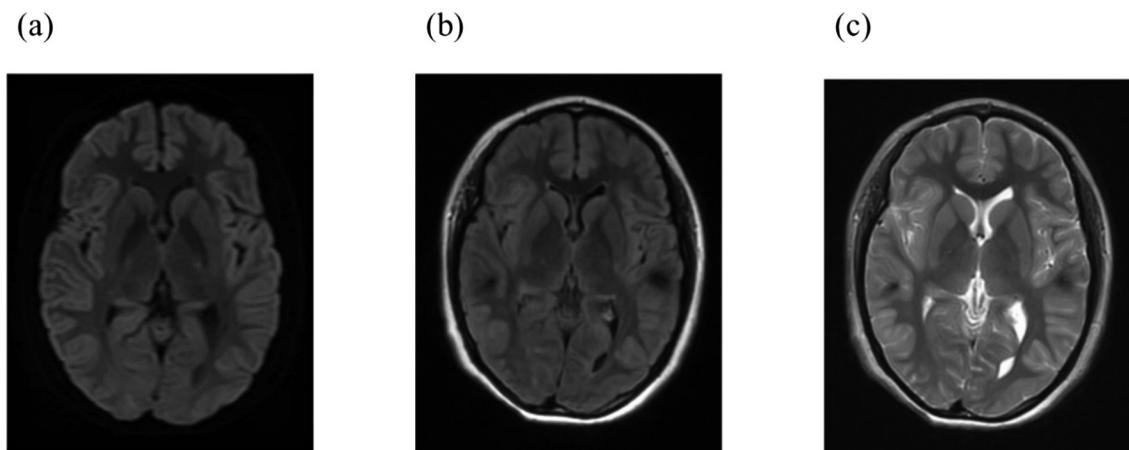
Brain magnetic resonance imaging showed no acute abnormalities.
